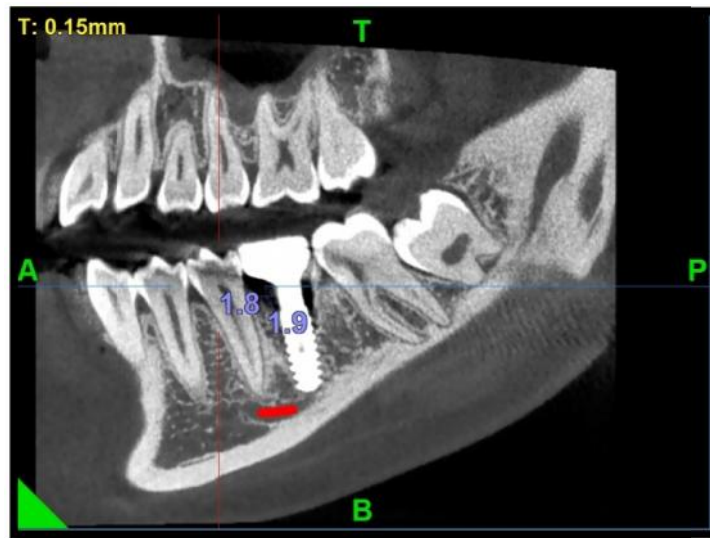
CBCT after 3 months of implant placement.
